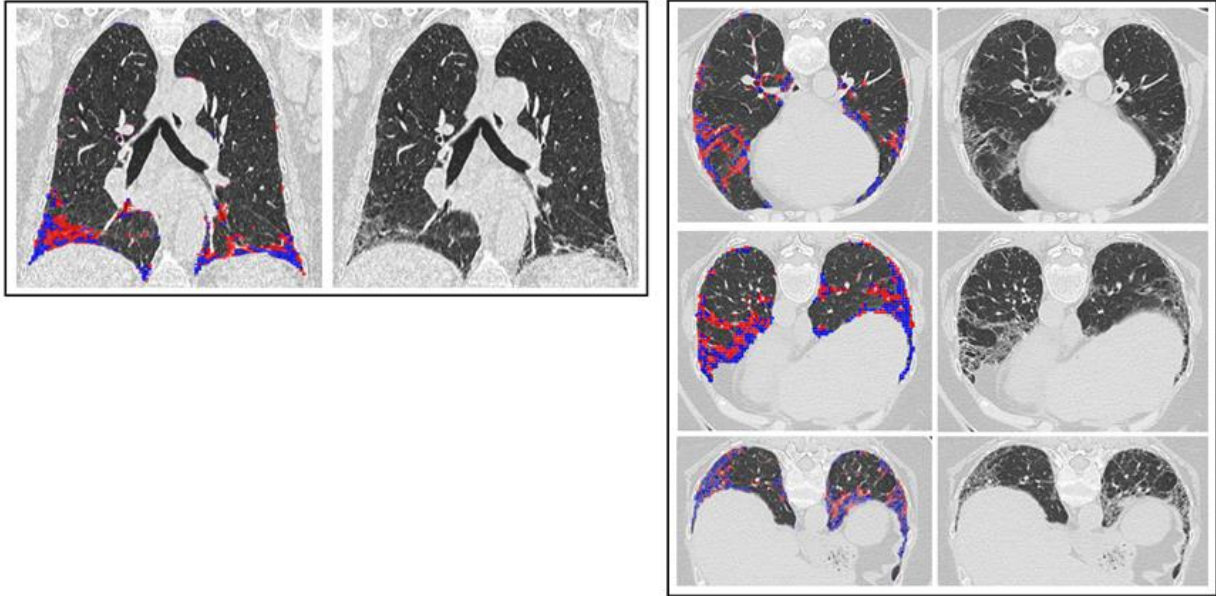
Coronal and axial computed tomography (CT) images with Quantitative Lung Fibrosis (QLF) characterization. Left: coronal (left) and original (right) coronal images. Right: Annotated axial high-resolution CT images with the classification of QLF (blue and red) and the corresponding original images. In whole lung, QLF extent is 10.6% and QLF score is 393 mL in volume. QLF scores in right and left lung are 11.5% and 9.5%, respectively. QLF scores were 20.1%, and 19.7% in the right and left lower lobes, which convert to 142mL and 105mL, respectively. QLF score quantifies the extent, and characterizes the distribution of pulmonary fibrosis as predominately lower lung disease. Courtesy of Prof. Grace Hyun J Kim and Prof. Goldin Jonathan.
